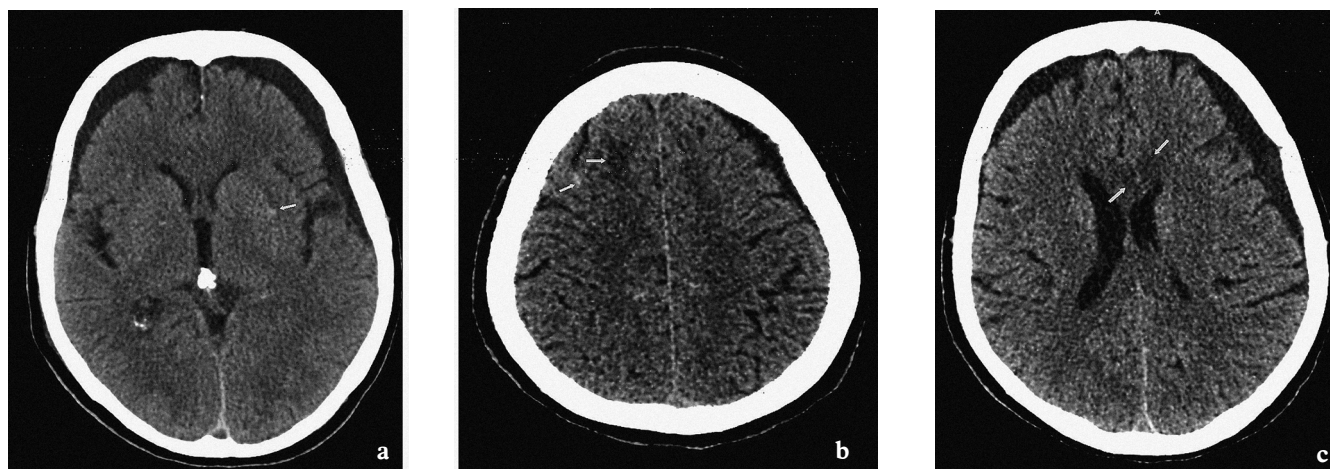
Axial CT, 18 days after DOI at the same level like in Figure 1. Partially resorbed hemorrhagic foci, hyper- and hypodense – arrows (a, b). Hypodense lesion in genu of corpus callosum is more evident than on the DOI (c).
